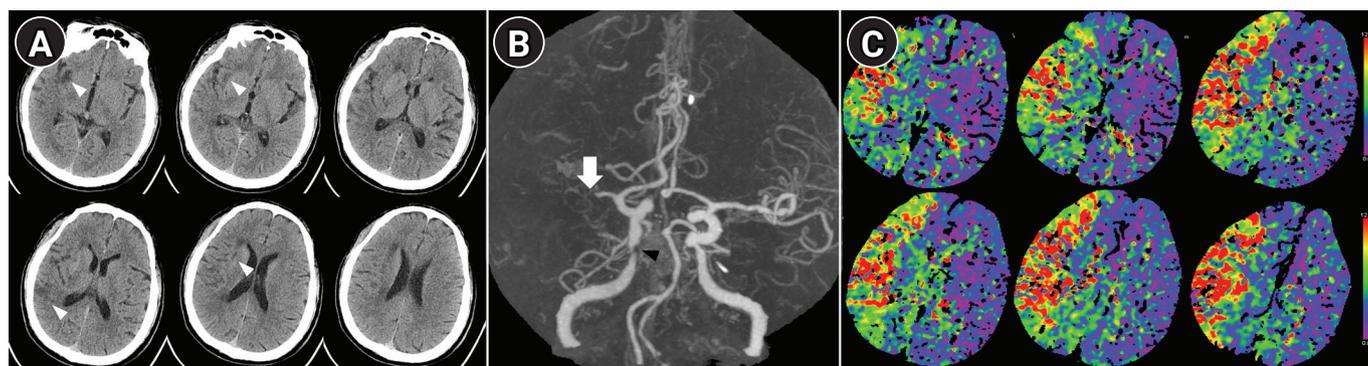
(A) Brain computed tomography without enhancement demonstrates low density in the right insula, corona radiate, and temporal lobe (white arrowheads). Sulcal effacement is also noted in right frontal and temporal lobe. (B) Brain computed tomography angiogram demonstrates occlusion of the M1 segment of the right middle cerebral artery (white arrow). Severe stenosis is also noted in the right distal internal carotid artery (black arrowhead). (C) Perfusion image shows increased T_{max} value in the right middle and posterior cerebral artery territory.
